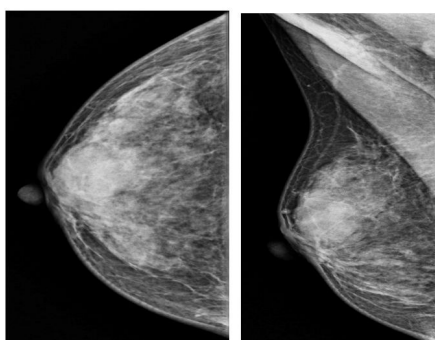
Example of mammography; right craniocaudal (CC) and mediolateral oblique (MLO) views of a 41-year-old woman, shows a round-shaped, circumscribed iso density mass at right upper-central region. The BI-RADS assessment = 2, Shape = 1, Margin = 1, Density = 2, and Severity = 0. The ultrasonography proven to be a cyst.
